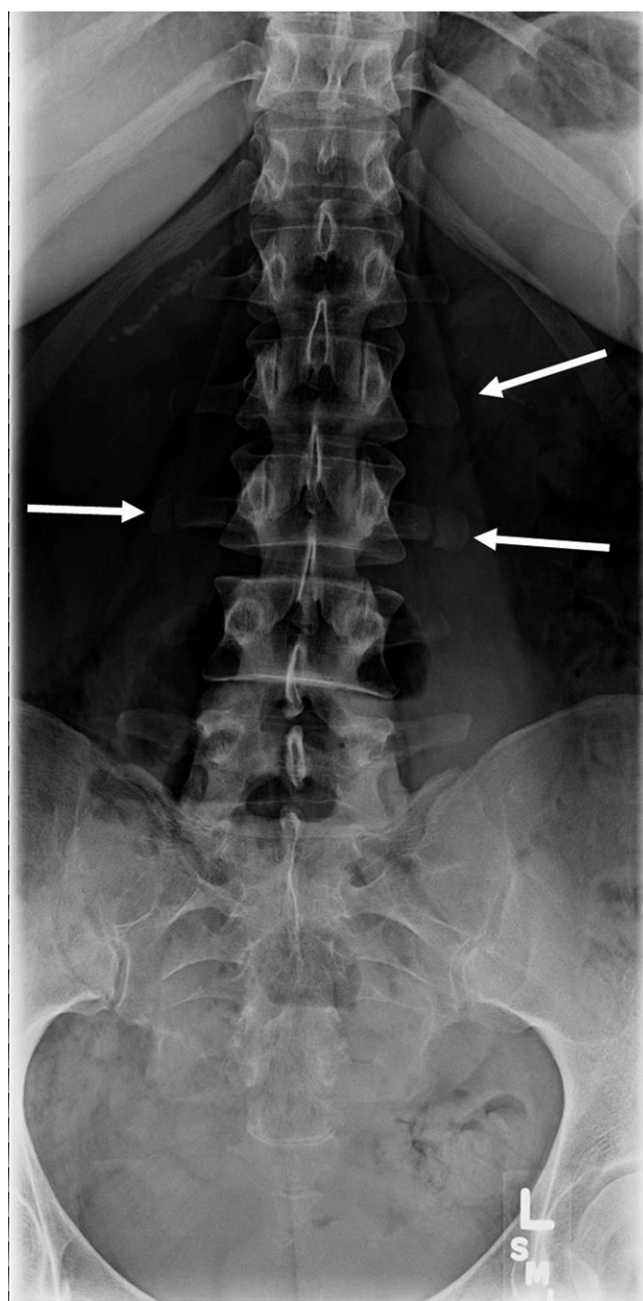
Plain film that was obtained 2 wk after training showing the fractures.
